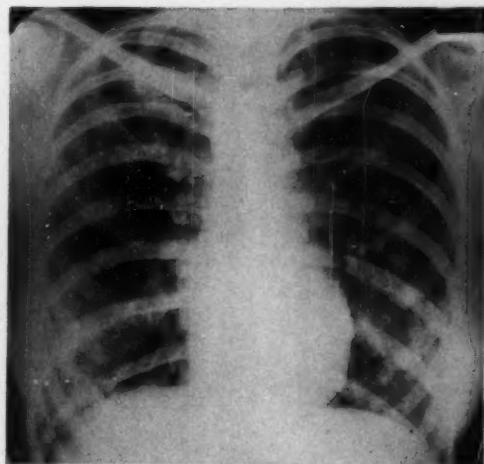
Case 1. Radiographic appearances one year later, showing bilateral disseminated patchy infiltration. Lung biopsy taken from right middle lobe three months after this film, when the radiographic appearances were similar.
